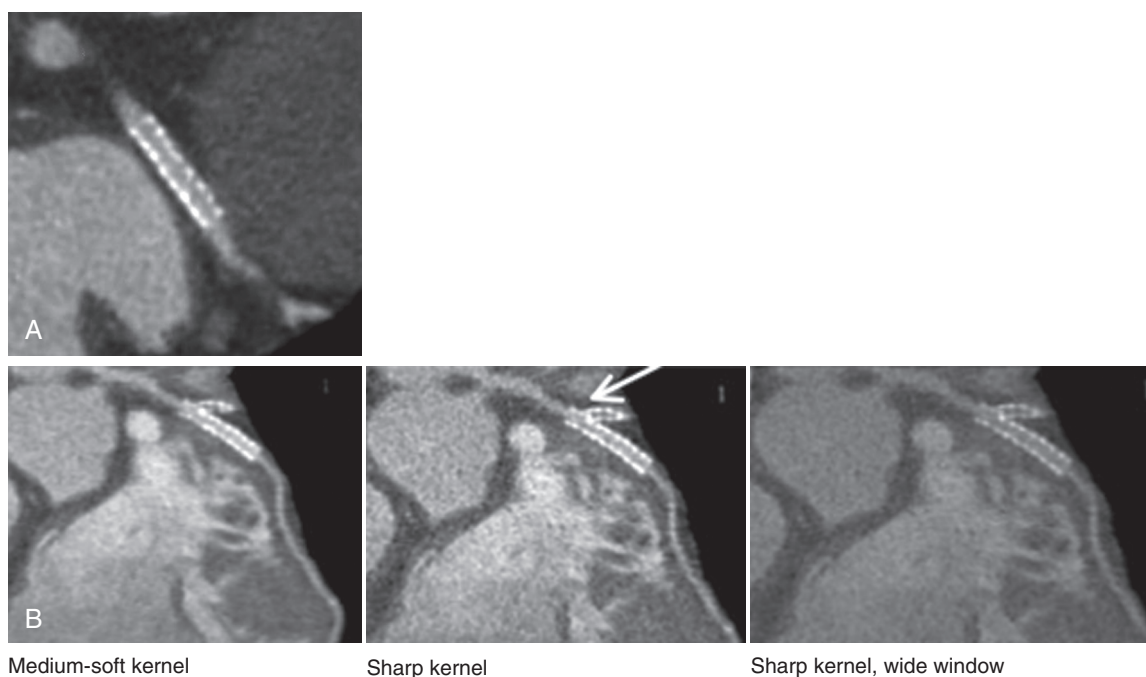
Stent imaging with cardiac CT. A, A large stent with uniform contrast attenuation in the lumen, indicating patency. B, A small stent in the left anterior descending artery with another stent in the proximal diagonal branch. Three reconstruction/display settings are shown: a medium-soft kernel, a sharp kernel, and sharp kernel reconstruction displayed with a wide window width. Visualization of in-stent restenosis in the diagonal branch is optimized with the third approach (i.e., sharp kernel, wide window display width). (Images courtesy Dr. John Lesser, Minneapolis Heart Institute, Minneapolis.)
